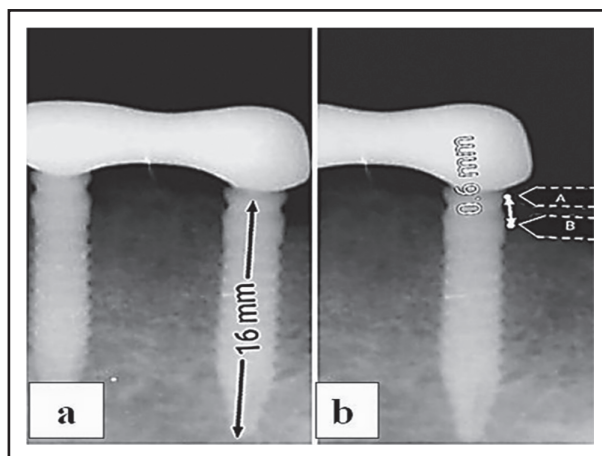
a: Measuring implant length in the radiograph. b: Bone height measurement in millimeters as the distance from point A (the implant neck) to point B (most coronal point of bone-implant contact).
